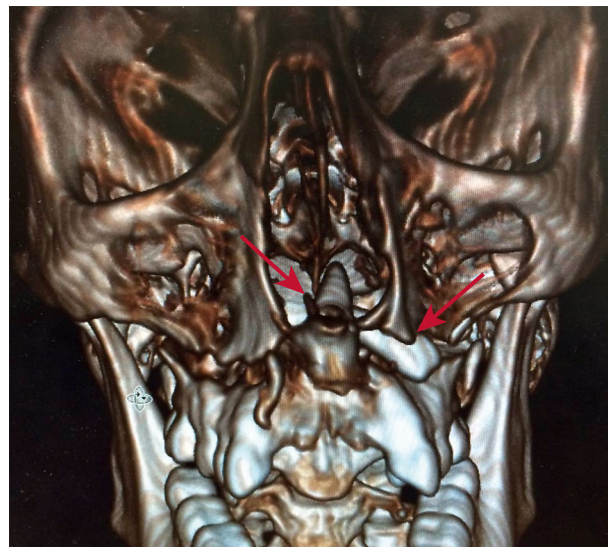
This patient suffered a road traffic accident resulting in both central incisors (red arrows) becoming lodged between his maxilla and floor of nose. At the time of the accident, paramedics were unaware of the tooth position until the patient was examined with CBCT
